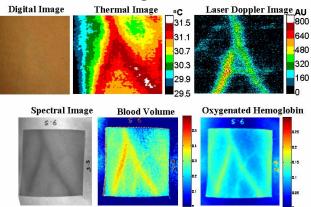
Typical example of images obtained from a non-KS patient using multi-imaging modality imaging techniques: thermal, laser Doppler, spectral, reconstructed tissue blood volume and reconstructed oxygenated hemoglobin.
